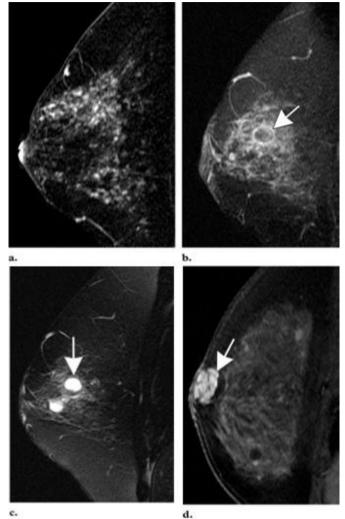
Benign features. (a, b) Contrast-enhanced T1-weighted fat-saturated gradient-echo (GRE) images from a 51-year-old woman show regional micro nodular (<5 mm stippled or punctate) enhancement in fibrocystic breast tissue (a) and rim like enhancement around a cyst (arrow in b) within a region of fibrocystic breast tissue. (c) T2-weighted fat-saturated image shows the cyst (arrow). (d) Contrast-enhanced T1-weighted GRE subtraction image from a 44-year-old woman shows an oval mass with smooth and lobular margins and enhancement with dark internal septa, typical of a fibroadenoma (arrow).
